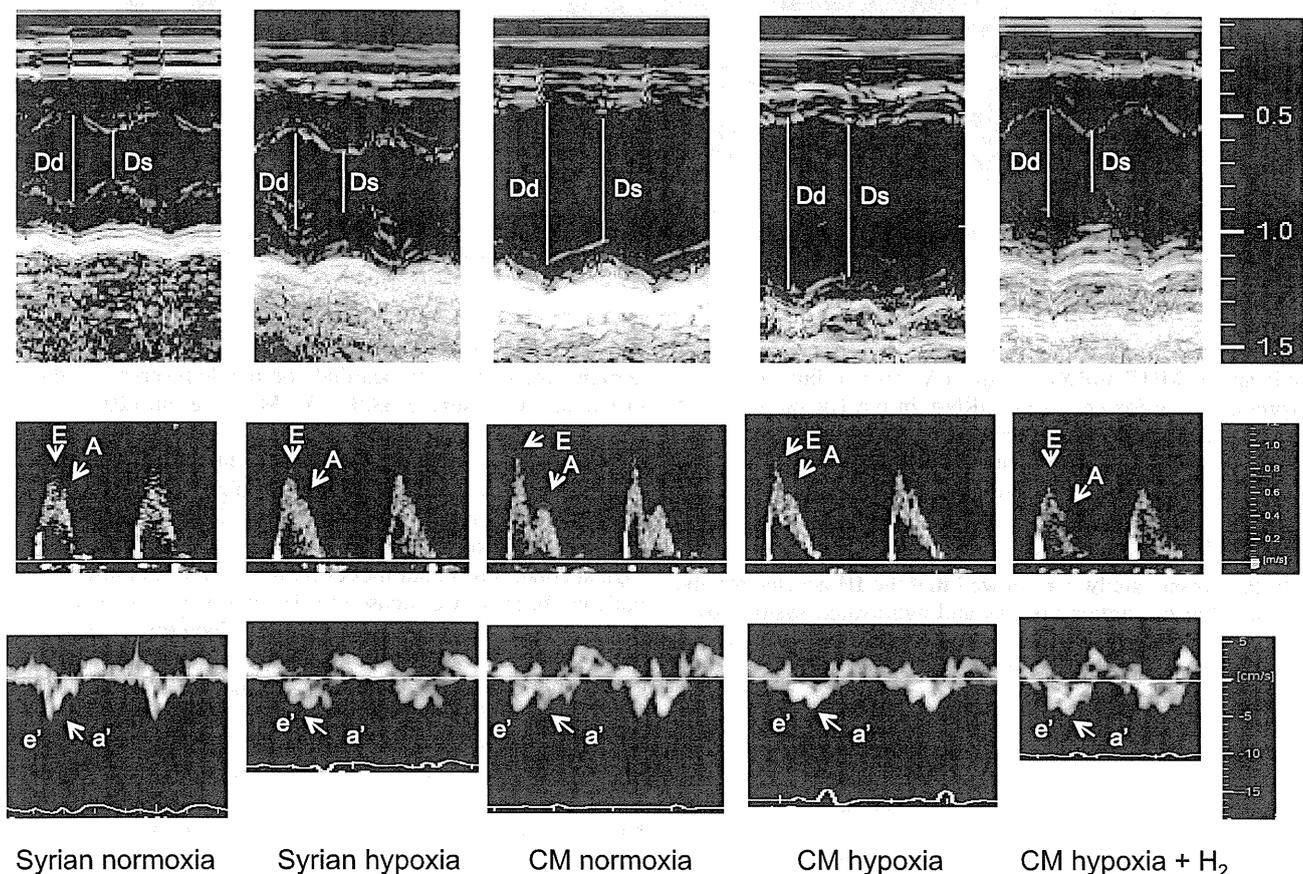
Echocardiographic findings after 2 wk of intermittent hypoxia. Changes in left ventricular (LV) end-diastolic diameter (D_d), LV end-systolic diameter (D_s), pulsed-wave Doppler parameters [early rapid filling wave (E) and atrial contraction wave (A) of mitral inflow], and tissue Doppler parameters [early (e') and late (a') velocities of the mitral annulus]. Note that the quantitative data are summarized in Table 2.
